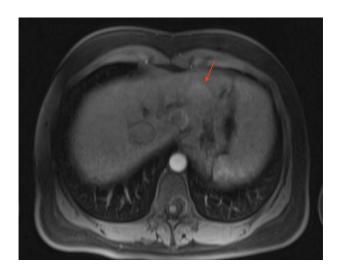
Axial contrast-enhanced MRI of the abdomen in the late arterial phase demonstrates a 2.4 cm arterially enhancing lesion compatible with an adenoma (red arrow) in segment 2 of the left hepatic lobe.
